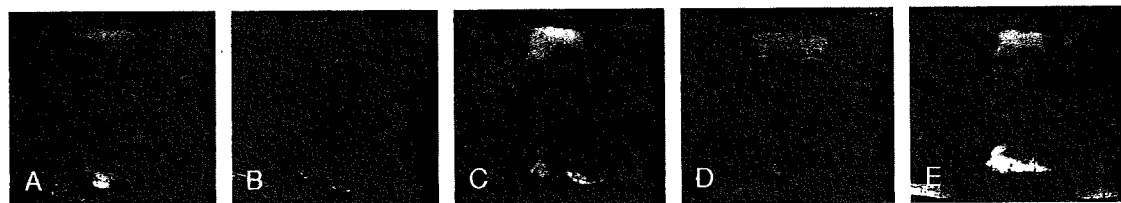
Serial axial T2-weighted images of sacral chordoma in a 61-year-old man. The tumor was temporary enlarged after carbon ion radiotherapy and then gradually shrank. A, Before carbon ion radiotherapy. B, At the end of carbon ion radiotherapy. C, Thirteen months after CIRT. D, Twenty-three months after CIRT. E, Forty-five months after CIRT.
